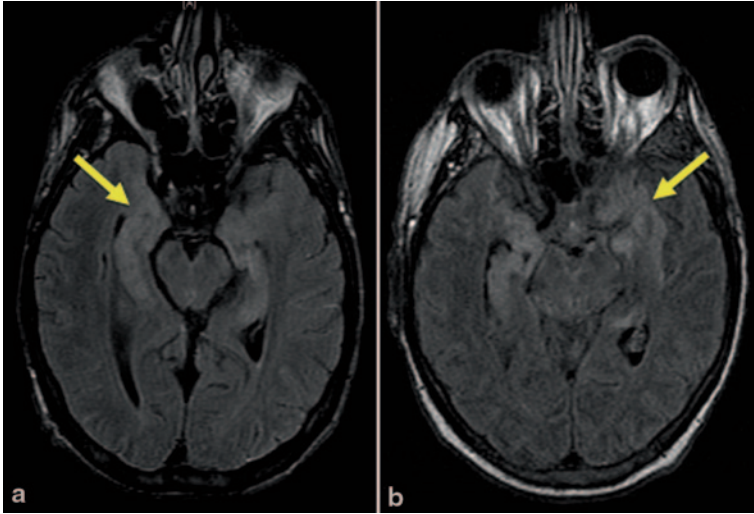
Axial MRI images from two patients with HHV-6 limbic encephalitis demonstrating T2/FLAIR hyperintensities of bilateral medial temporal lobes (*arrows*) (Hill et al. 6). (Reprinted with permission from: Hill et al. 2012)
